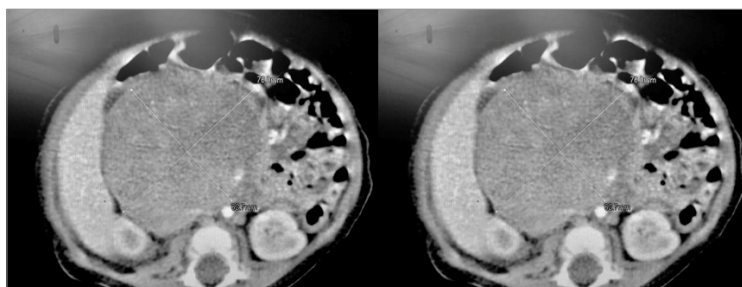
CT scan shows a very big mass and vena cava is infiltrated.
